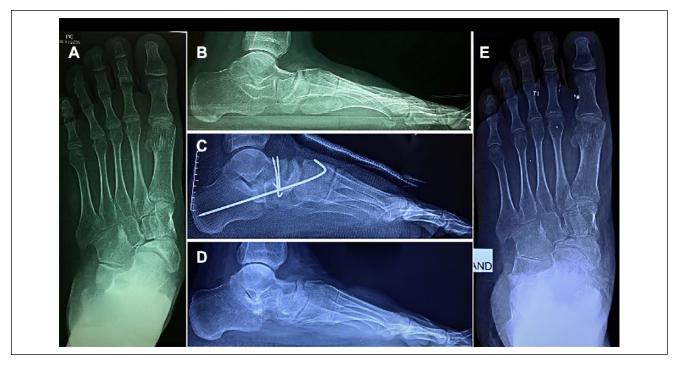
A case of Müller-Weiss disease. (A, B) Preoperative radiographs showing the comma-shaped navicular with forefoot abduction and arch collapse without osteoarthritis. (C) Immediate postoperative lateral radiograph after calcaneal lengthening osteotomy with fixation by K-wires. (D, E) Postoperative radiographs after 2 years showing restoration of the arch.
